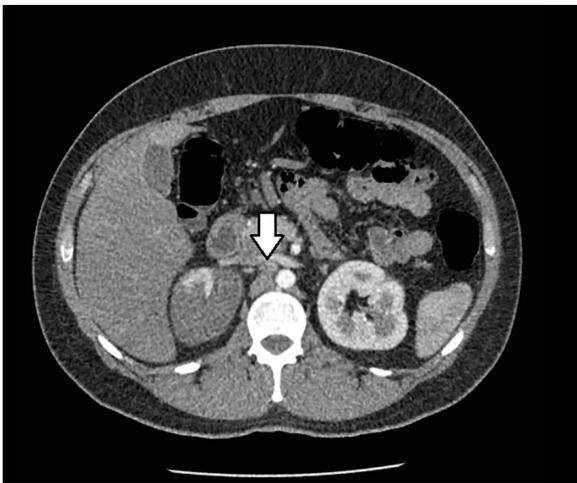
Abdominal computed tomography scan showing one of the thrombi extending to right renal artery ostium and causing partial occlusion of the proximal segment of this artery (arrow). Right kidney presents hypodense areas compatible with renal infarcts.
